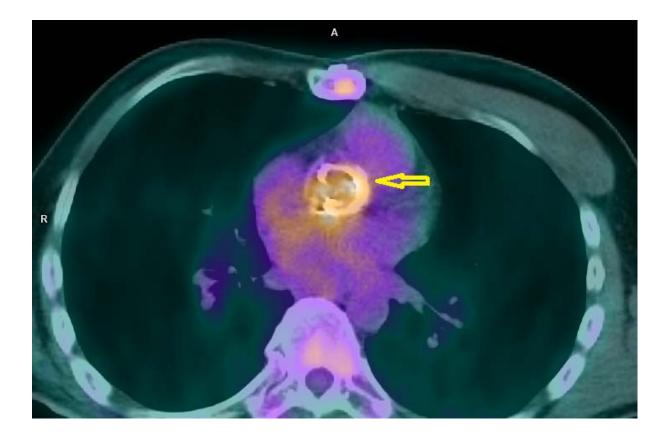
Fusion images of PET/CT performed for diagnosing infective endocarditis. Images were acquired with a Biograph 64 PET/CT scanner (Siemens Medical Solutions, Inc.) 60 minutes after injection of 330 mBq [18F]FDG. Presented image shows transversal, fused PET/CT image, corrected for attenuation. Yellow arrow shows increased radiotracer uptake in aortic annulus consistent to infection. The semiquantitative PET/CT analysis was performed using the SYNGOVIA application. Standardized uptake value (SUVmax) for valve area was 3.4; reference (myocardial blood pool [MBP] was 2.1, liver SUVmax 2.9).
